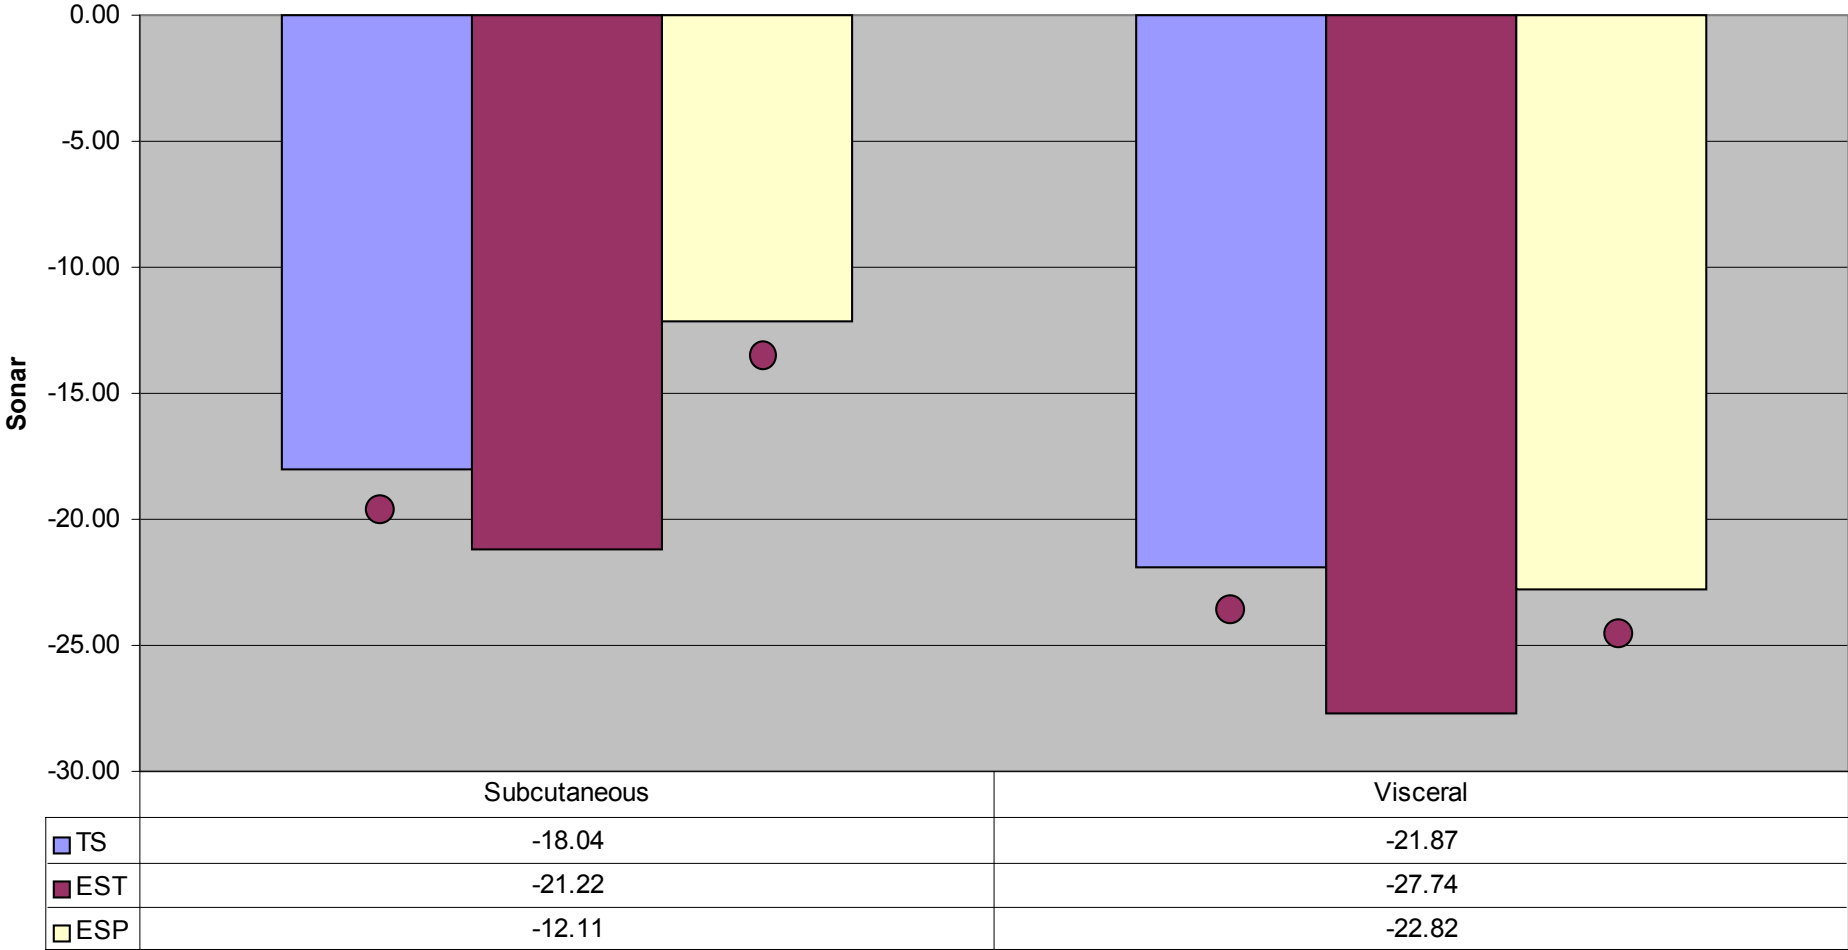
Ultrasound Sonography Responses between Groups
